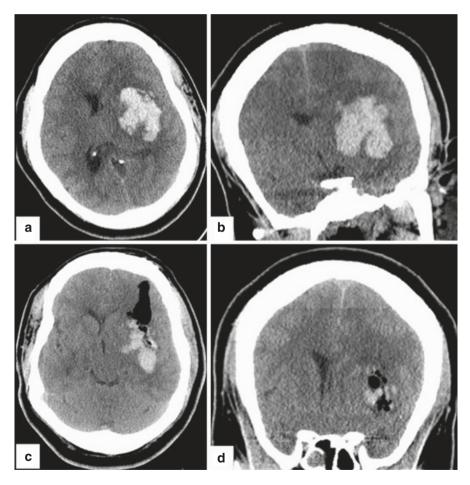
A 45-year-old African American female presented with sudden onset aphasia and right hemiparesis. (\mathbf{a} , \mathbf{b}) Axial and coronal CT scans demonstrating a large basal ganglia hemorrhage. (\mathbf{c} , \mathbf{d}) Vascular lesion was ruled out, and patient was taken to the OR for image-guided minimally invasive endoscopic evacuation of hematoma
